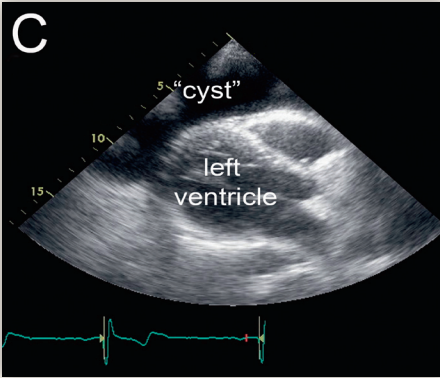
Transthoracic echocardiography showing a large echolucent space around the heart (parasternal long-axis view).
